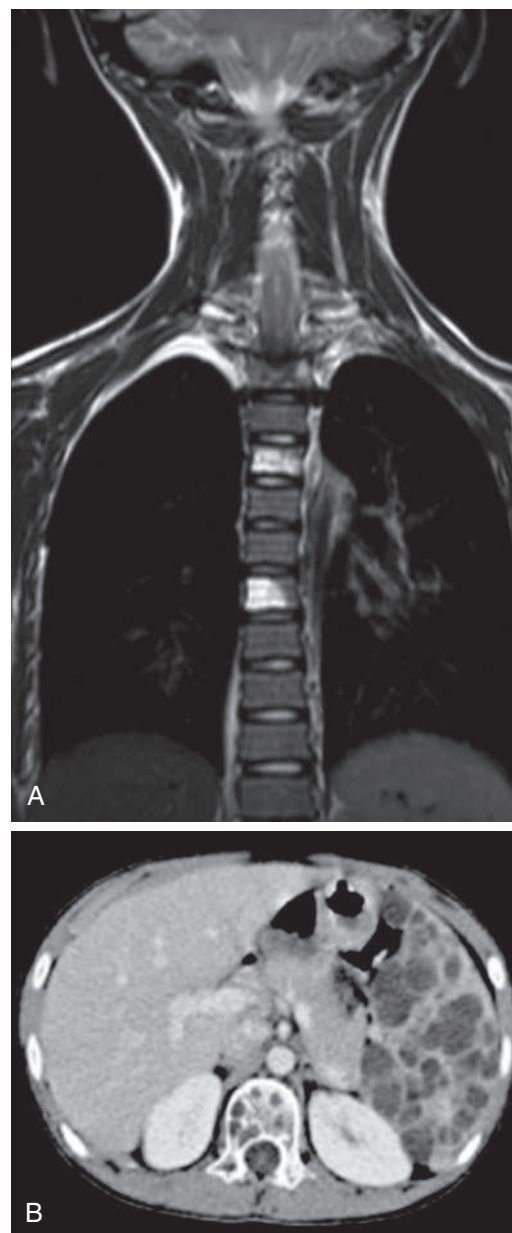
A, MRI imaging of vertebral body lymphatic malformations in a patient with generalized lymphatic anomaly (GLA). B, Splenic and vertebral body lesions in a patient with GLA. (B from Joshi M, Phansalkar DS. Simple lymphangioma to generalized lymphatic anomaly: role of imaging in disclosure of a rare and morbid disease. *Case Rep Radiol.* 2015;2015:603859.)
